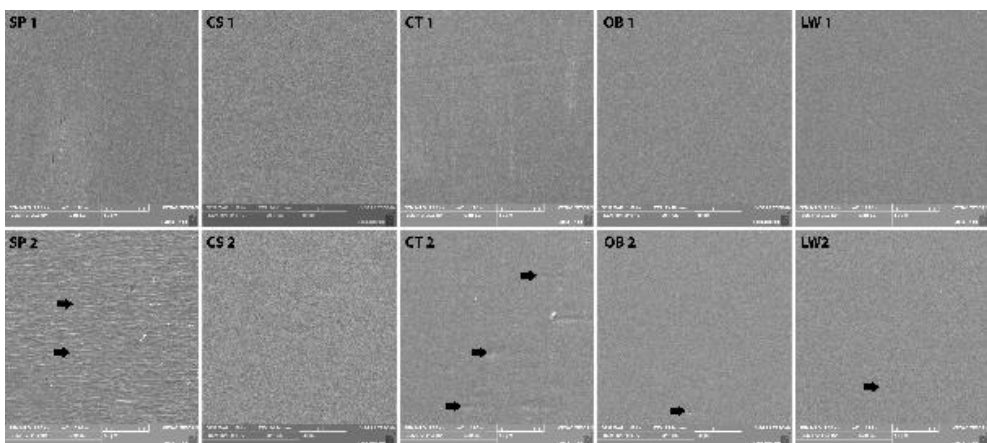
Representative SEM images of the IPS material e.max CAD, with a magnification of $\times 1000$, from before (1) and after brushing (2) with sensitivity (SP and CS), regular (CT), and whitening (OB and LW) toothpastes. The black arrows point to the cracks or scratches caused by brushing.
